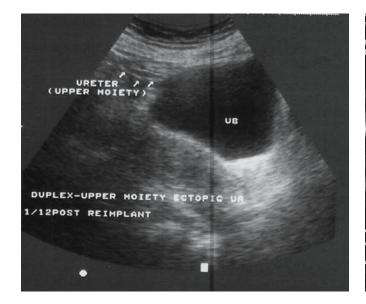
Postoperative ultrasound scan shows the distal ureter entering the bladder
